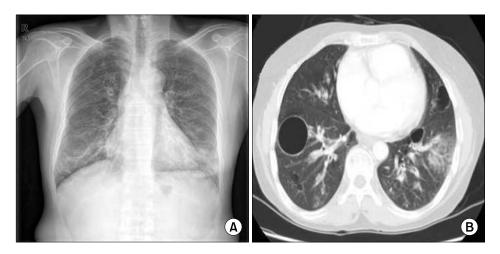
Chest radiographs and computed tomography at second time visit. (A) Chest radiographs showing multiple cystic lesions combined with pneumonic infiltration in both lower lungs, and (B) chest CT showing multiple cystic lesion of variable-size and some consolidations in both lower lungs with bronchovascular bundle thickening.
